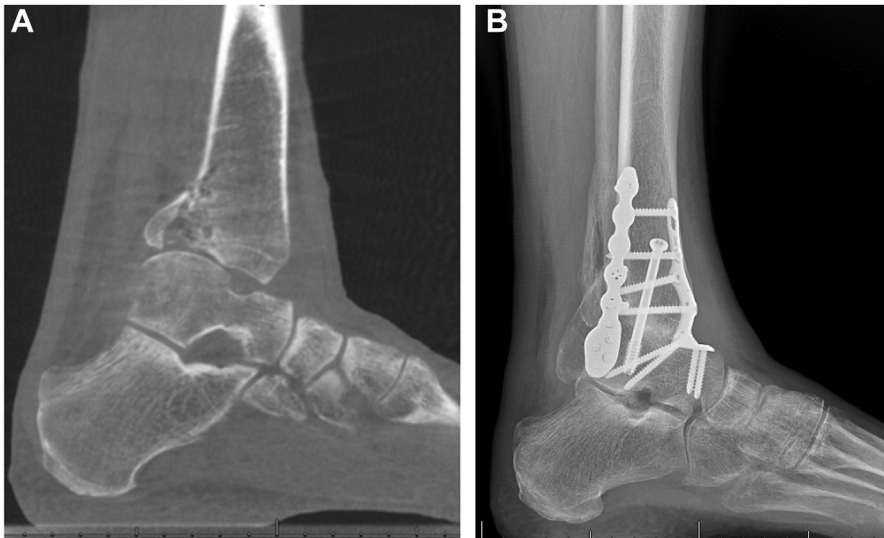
(A) Lateral ankle radiograph showing posttraumatic ankle arthritis and significant posterior translation of the talus secondary to untreated posterior malleolus fracture (B).
